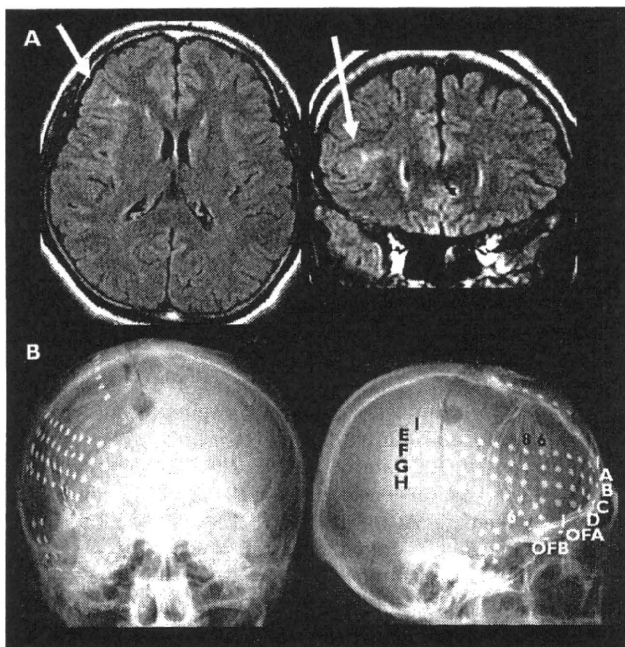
MRI lesion and subdural electrodes (Patient 2). (A) Brain MRI with FLAIR sequences showing a high intensity area in the right frontal operculum (arrow). (B) X-ray photographs showing subdural electrodes. Subdural grid electrodes were implanted over the right fronto-temporal, and parietal areas.
